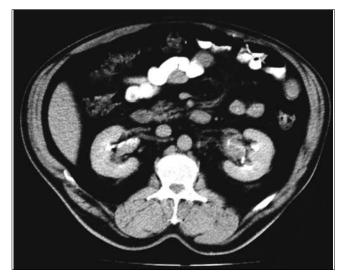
CT scan demonstrating large volume bilateral renal pelvis tumors.
